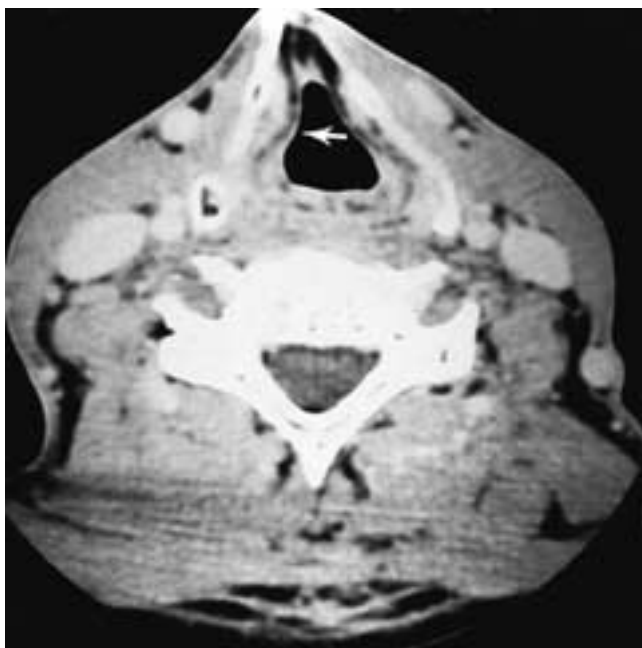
Axial CT. Asymmetrical shape of the thyroid cartilage causing a slight bulge in the supraglottic larynx (*arrow*), which could be confused with a submucosal tumor.
